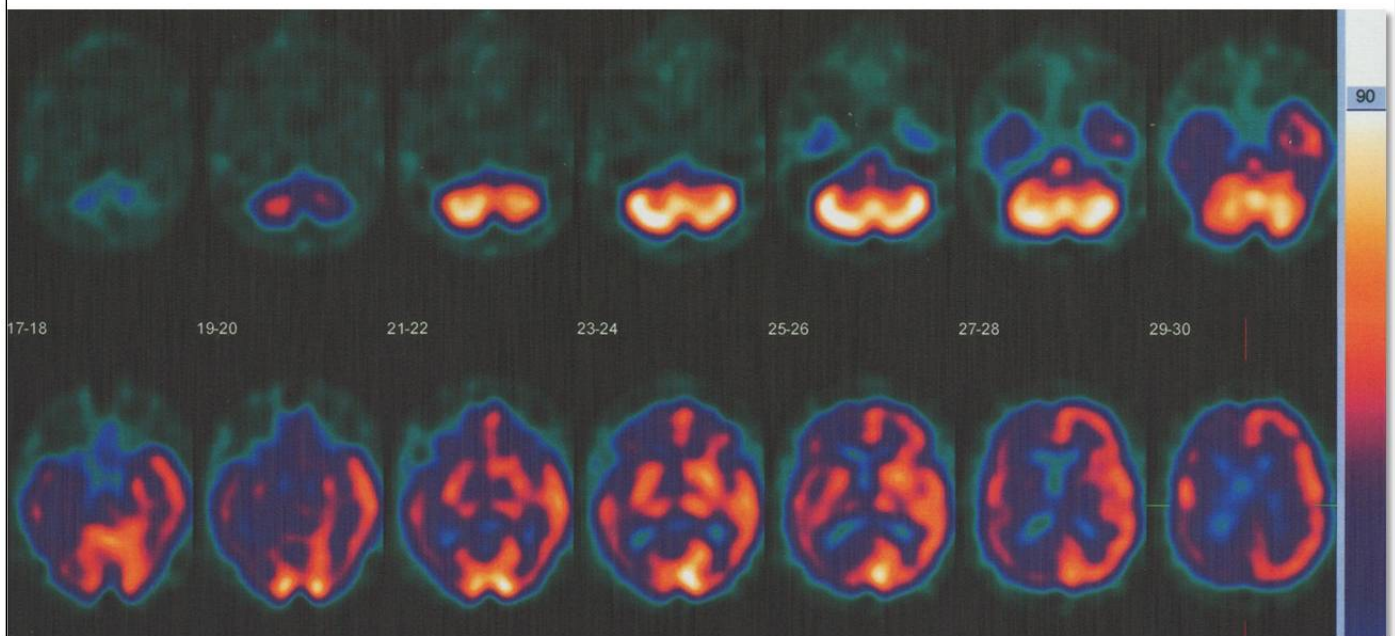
Single Photon Emission Computerized Tomography (99mTc SPECT) study at admission.
